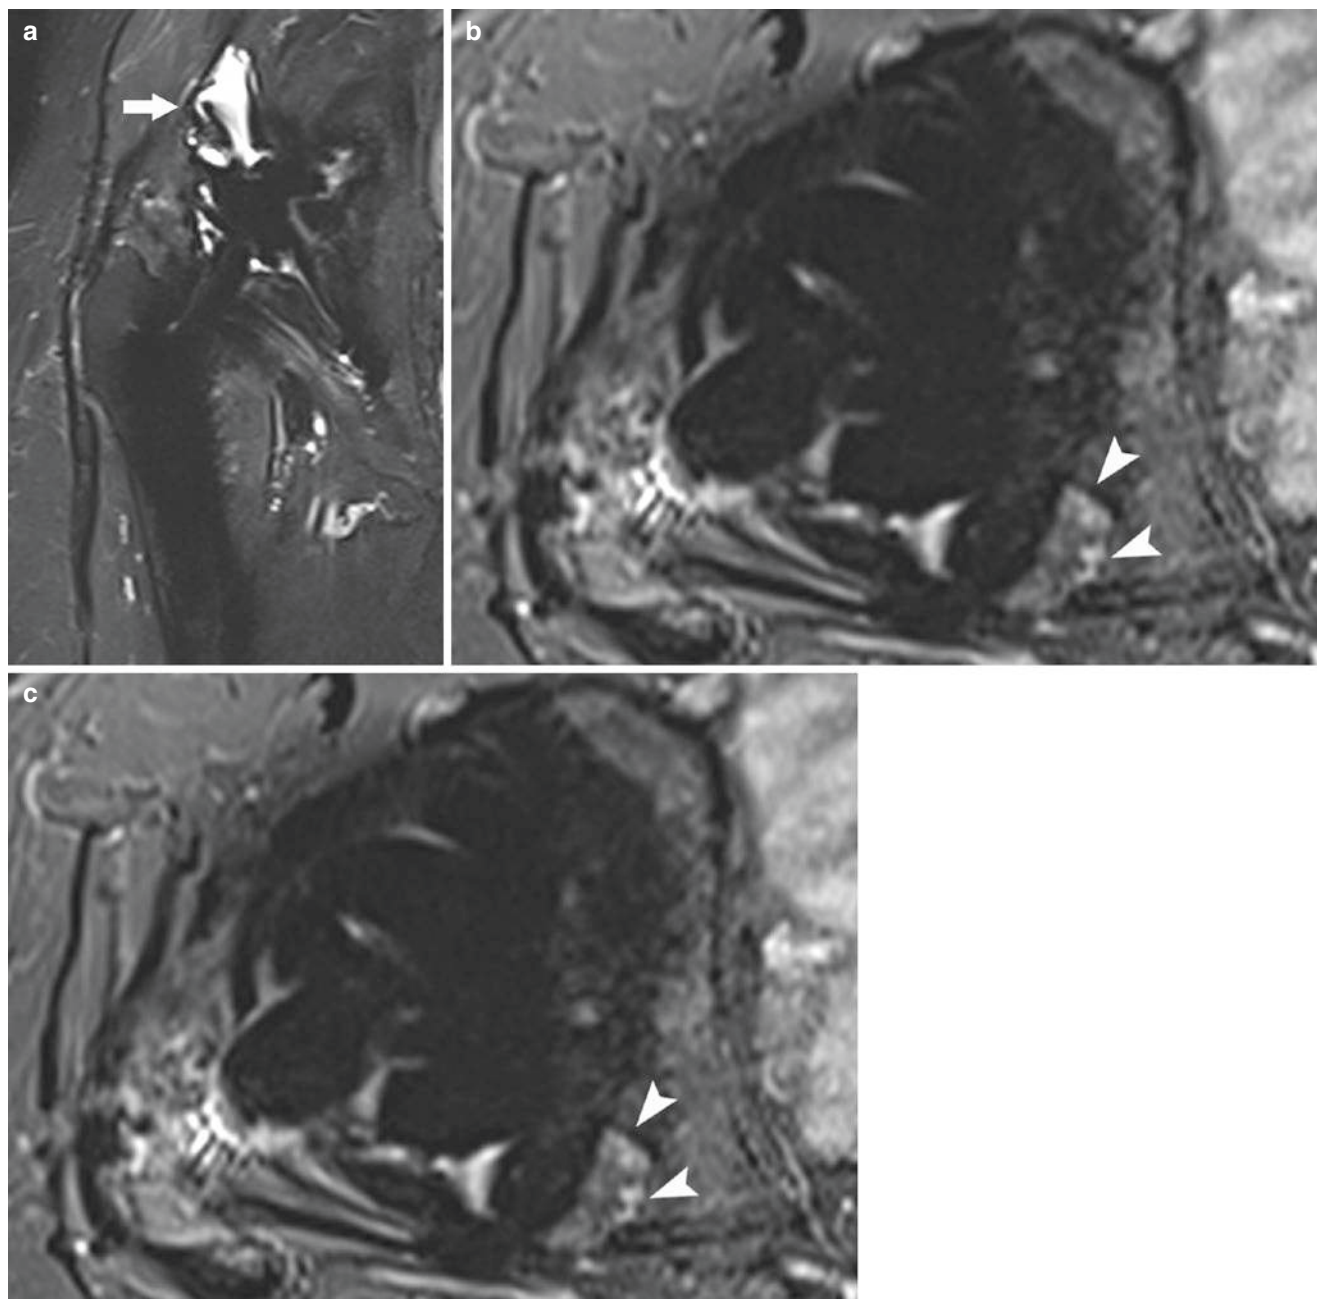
55-year old female with painful total hip arthroplasty. MRI of the right hip reveals a cyst-like collection in the periarticular soft tissue (arrow in a), referred to as a pseudotumor. A periprosthetic osteolysis
